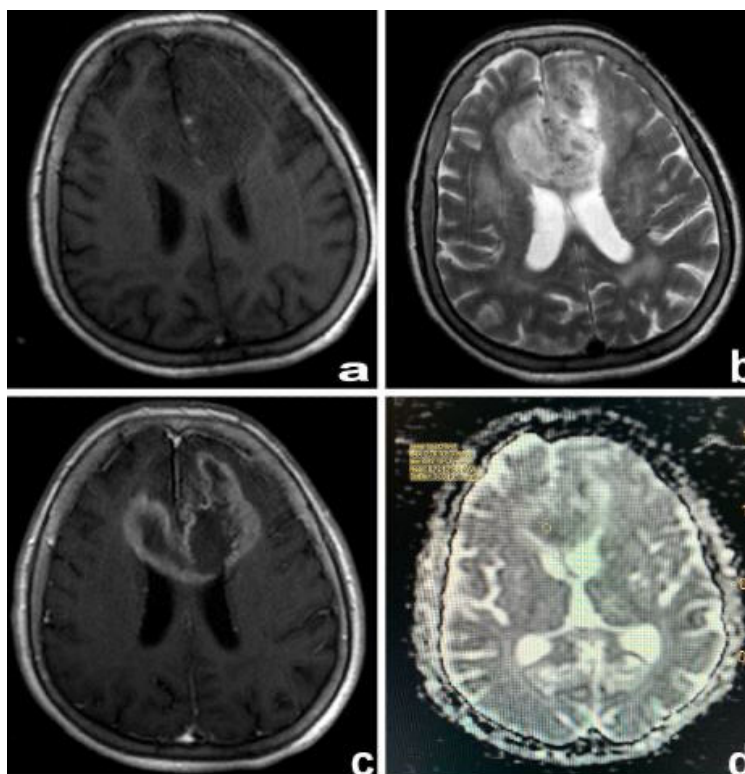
A 73-year-old female patient has a lesion with a diameter of 62 mm located at the frontal region. Hyperintense foci determined as hemorrhage are seen in T1WI (a). It is observed that the lesion is shifted on contrast-enhanced T2W and T1W images, extends from the midline to the opposite hemisphere, contains large areas of necrosis, has irregular contours, shows intense contrast enhancement, has a small amount of peritumoral edema, and is heterogeneous only on T2W (b, c). A total of score was 17 obtained from their morphological features. ADC value of 0.72×10^{-3} mm²/sec was obtained (d) from the areas showing tumoral enhancement. T1WI and T2WI = T1- and T2-weighted axial imaging, ADC = apparent diffusion coefficient.
